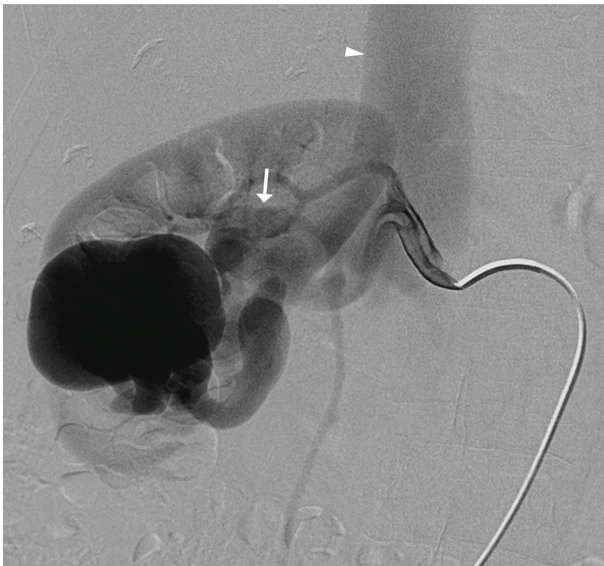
Volume-rendered computed tomography angiography (A) showing giant cirsoïd aneurysmal dilations of right renal artery with early opacification of right renal vein (arrow) and inferior vena cava (arrowhead), indicating of congenital renal arteriovenous malformations (AVMs). Therefore, right renal artery angiography (B) confirmed the diagnosis of right giant renal AVMs by demonstrating cirsoïd arterial communication with early visualization of right renal vein (arrow) and inferior vena cava (arrowhead).
